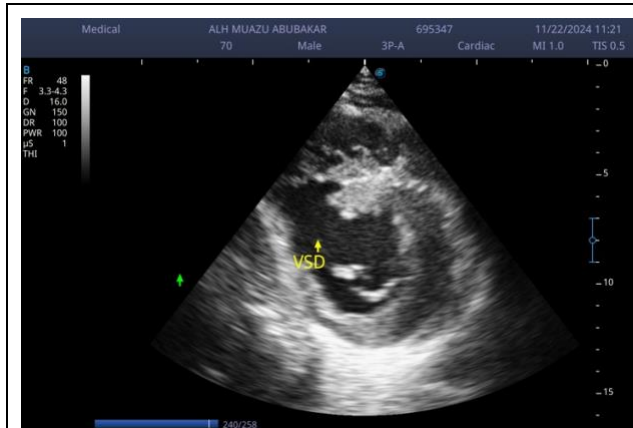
Parasternal short axis view showed echo drop out along interventricular septum in keeping with acquired ventricular septal defect (VSD).
